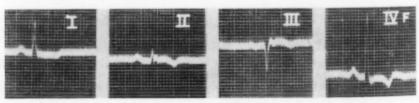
Ventricular aneurysm diagnosed by roentgenography. Tracing shows depressed ST and biphasic T<sub>1</sub>, inverted T<sub>2</sub>, prominent Q, elevated ST, and inverted T<sub>3</sub>, depressed ST and biphasic T<sub>1</sub>, The aneurysm was situated in the posteroapical portion of the left ventricle.
